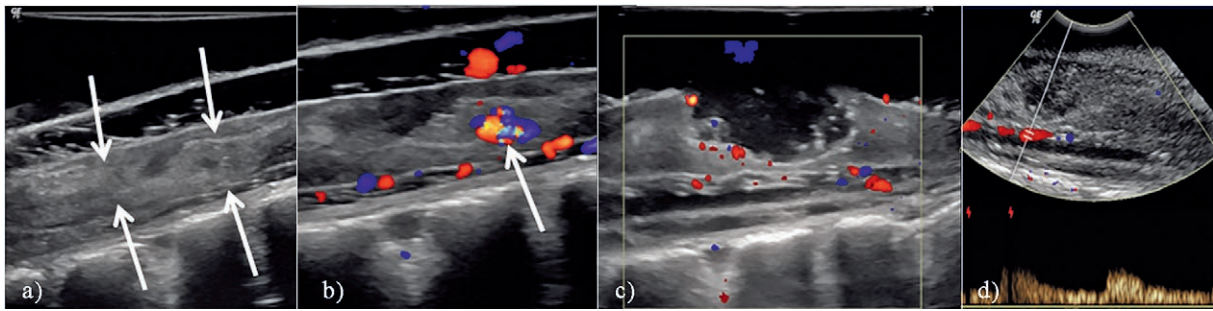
IOUS (a) showed intramedullary multilobulated hyperechogenic and isoechogenic focal areas in the distal spinal cord at the level T11-12 (arrows), the color Doppler ultrasound (b) showed high-velocity, high turbulence vessels within a focal nodular component in the proximal part of the hemorrhage that was thought to belong the nidus (arrows). Following a midline myelotomy, after resection of the multilobulated focal hemorrhagic areas and a nodular component the repeated the color Doppler IOUS (c), showed no intramedullary vascular lesion. The ASA flow was demonstrated with spectral Doppler ultrasonography (d).
